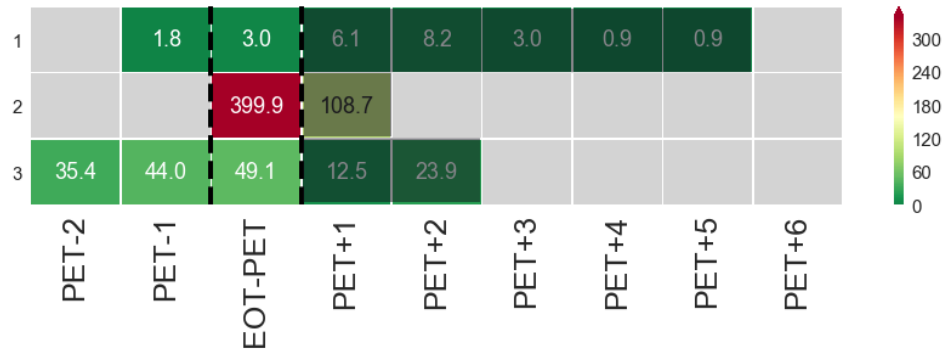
Total lesion glycolysis in positive EOT FDG-PET non-progressing NCI patients.
